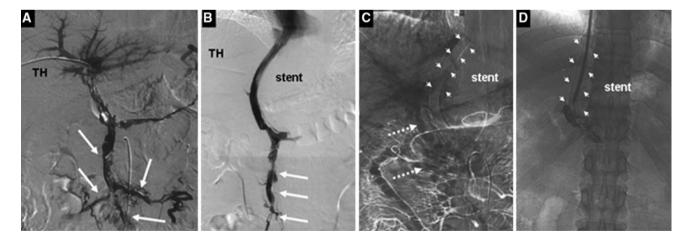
Unnecessary stent-placement in a patient with extensive thrombosis within the SMV branches. Direct portography via a percutaneous transhepatic approach showed diffuse thrombosis within the portal venous system (*panel A*). After a stent was successfully created, there was still diffuse thrombosis within the SMV branches (*panel B*). One month later, color Doppler ultrasonography revealed
